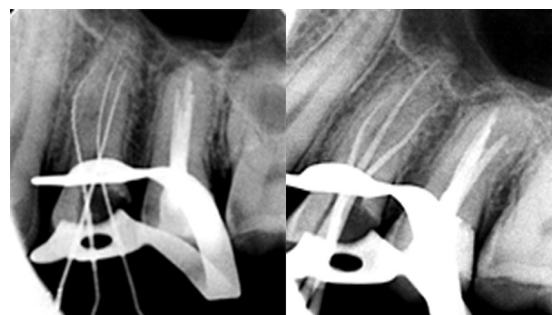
Radiographical confirmation of three root canals and determination of the working lengths.
